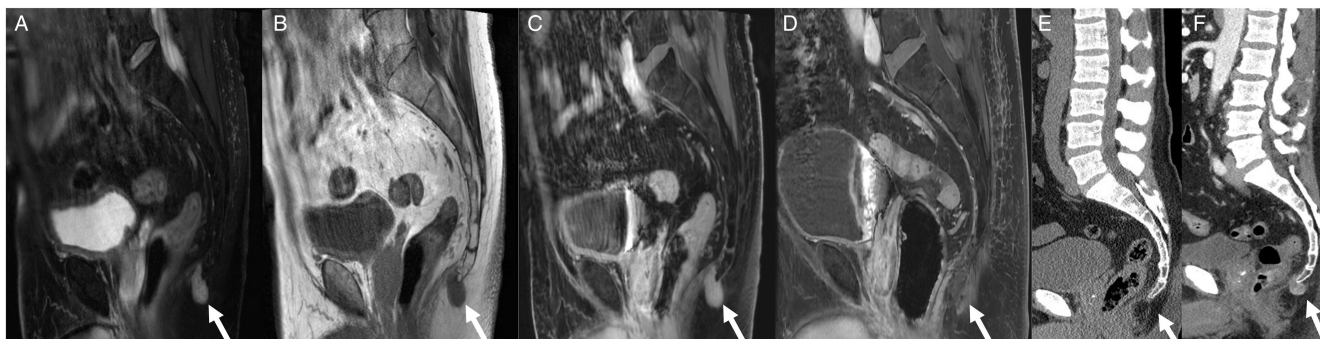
Magnetic resonance imaging of coccygeal tumor. a) T2 fat saturated image showing hyperintense $1.8 \times 1.4 \times 2.4$ cm coccygeal mass, b) T1 precontrast image showing hypointense mass that c) homogeneously enhances on post contrast images, d) T1 post contrast MRI revealing gross total resection of mass, e) noncontrast CT imaging of the pelvis 13 years prior to presentation showing no apparent lesion, f) that was noted on repeat CT pelvis with contrast obtained 15 months prior to MRI.
